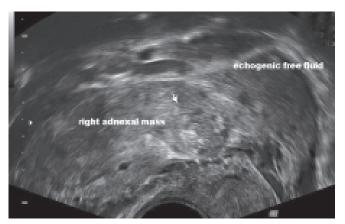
Transvaginal ultrasound scan demonstrates a complex adnexal mass in a patient presenting with amenorrhea, pelvic pain and positive pregnancy test
